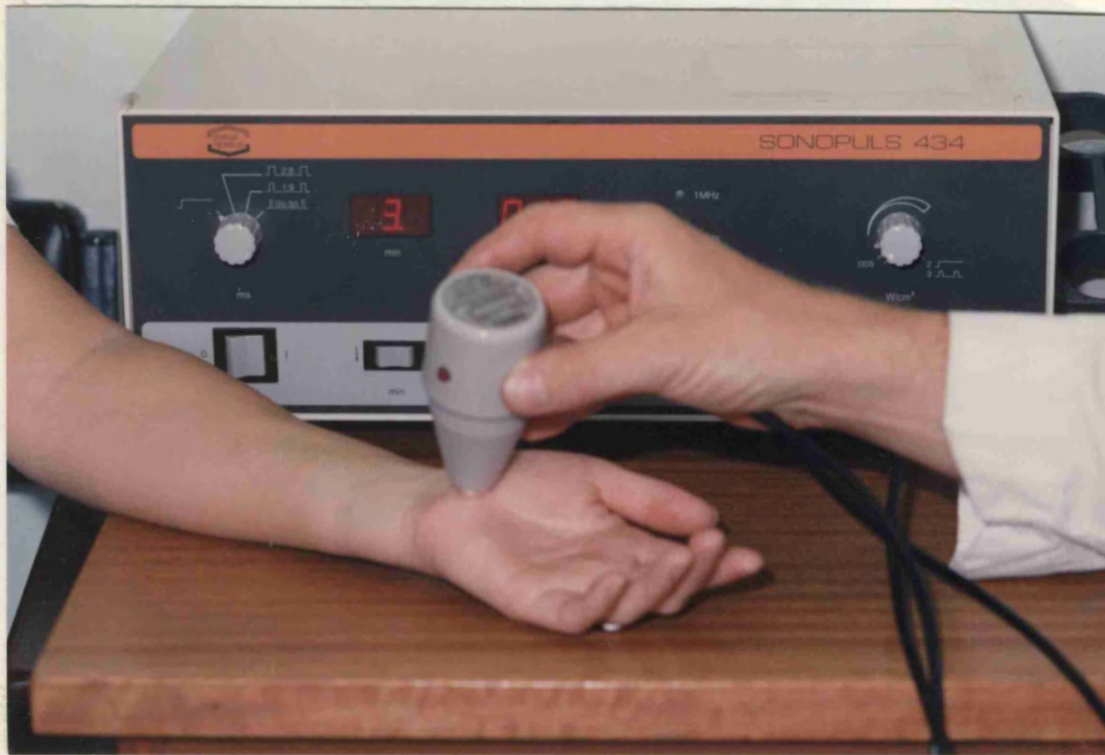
Using a Sonopuls 434 ultrasound unit to detect carpal tunnel syndrome.
